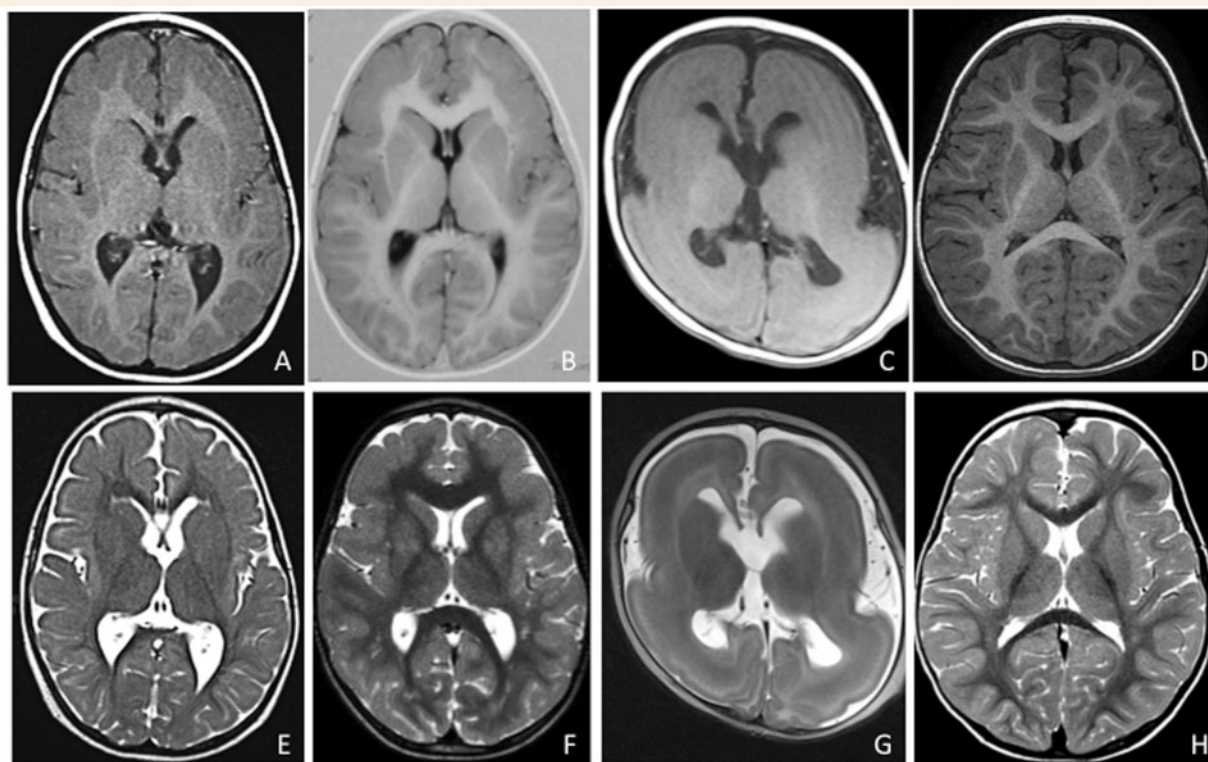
Representative T₁-weighted (A, B and C) and T₂-weighted (E, F and G) axial section of MRI in three males with *DCX* mutations representing the most prominent LIS grade in this study. Anterior pachygyria (LIS grade 4) in a 2-year-old male (familial case) (A and E). SBH with anterior pachygyria in a 5-year-old male (familial case) (B and F). Severe lissencephaly (LIS grade 2) more severe anteriorly in a sporadic male aged 1 year 3 months (C and G). Control MRI: T₁-weighted image (D) and T₂-weighted image (H) in normal 18-month-old boy.
